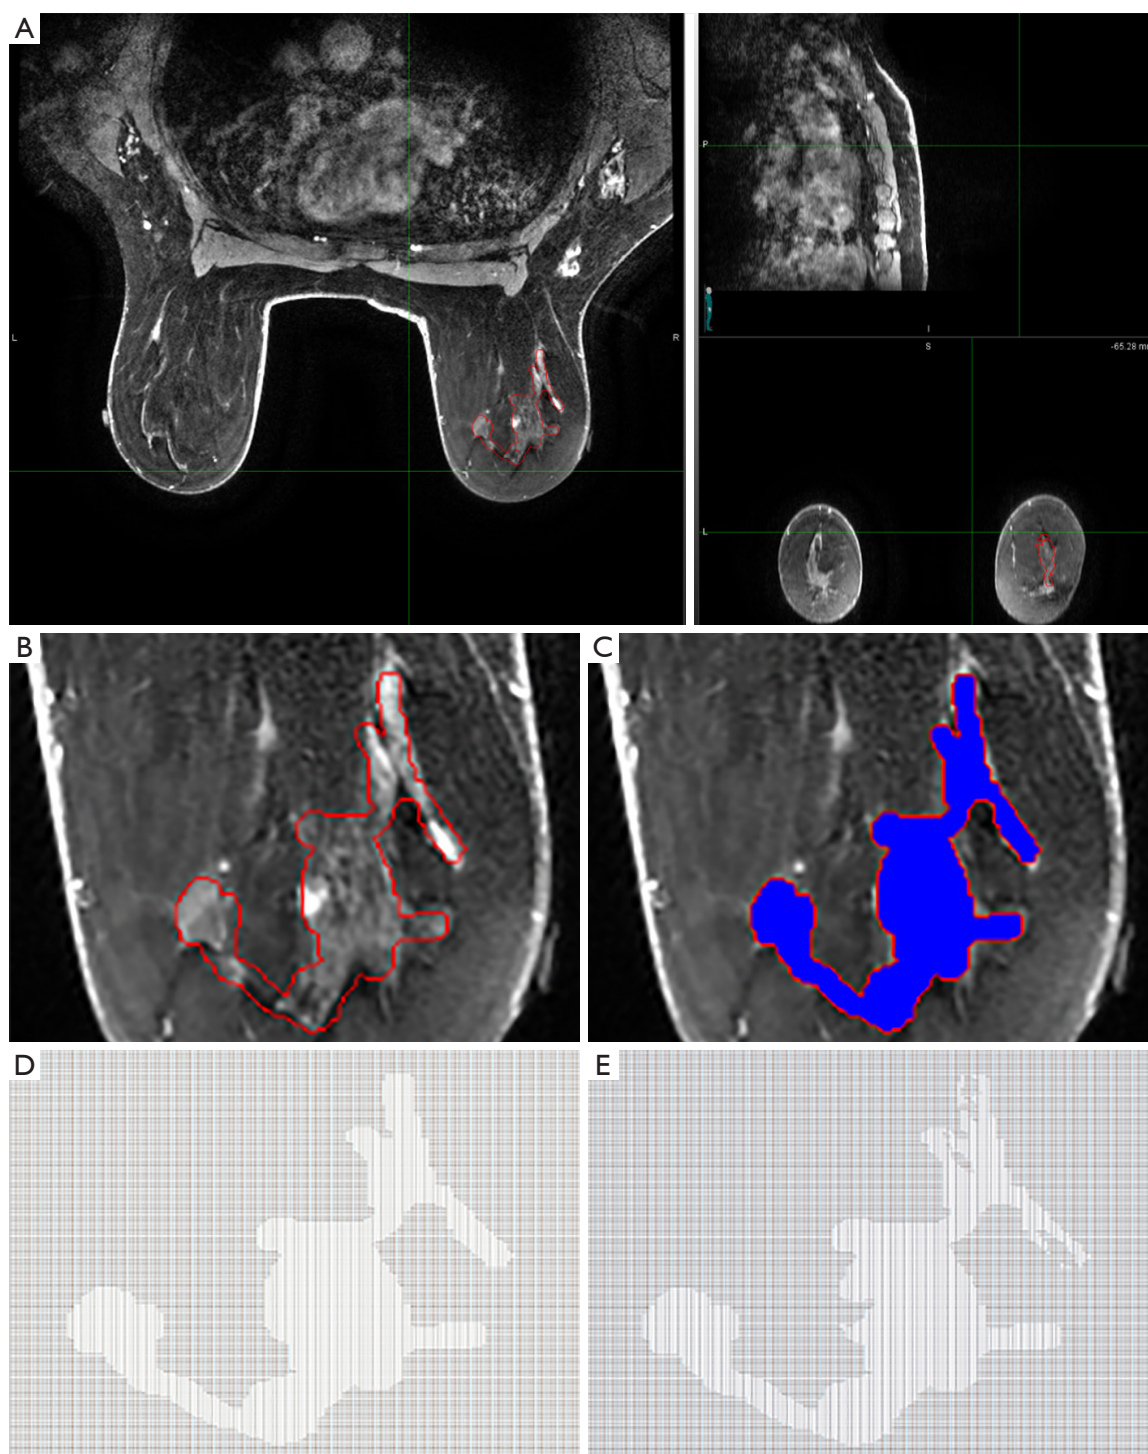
Visualization and pixel processing sequence of a DCE-MRI breast tumor slice. DCE-MRI scan of patient with breast cancer viewed in three orientations (A); focused 2D image displaying an axial slice of tumor (B) with superimposed blue background for regional recognition and processing (C); tumor recognition values without digital mature vessel filtration (D) and with (E) comprising a numerical data matrix representative of the image pixels, displayed from a much zoomed out perspective elucidating the processed tumor values (miniscule font series of “1”) contrasting the null (miniscule font series of “0”). DCE-MRI, dynamic contrast enhanced magnetic resonance imaging; 2D, 2-dimensional.
